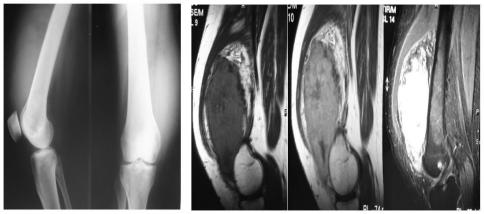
Standard radiography showing antero-internal soft tissue mass without periosteal reaction, and MRI: Heterogeneous tissue tumor measuring  $13 \times 10 \times 5$  cm.
